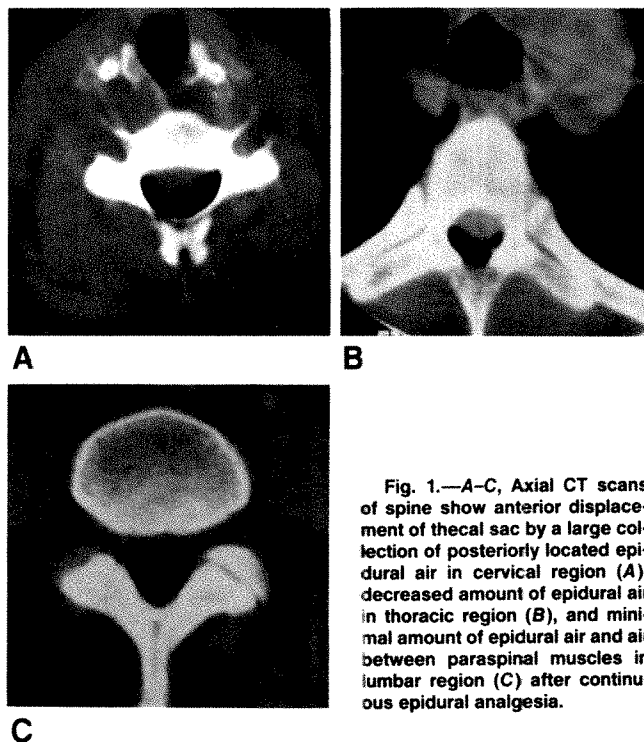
A–C, Axial CT scans of spine show anterior displacement of thecal sac by a large collection of posteriorly located epidural air in cervical region (A), decreased amount of epidural air in thoracic region (B), and minimal amount of epidural air and air between paraspinal muscles in lumbar region (C) after continuous epidural analgesia.
